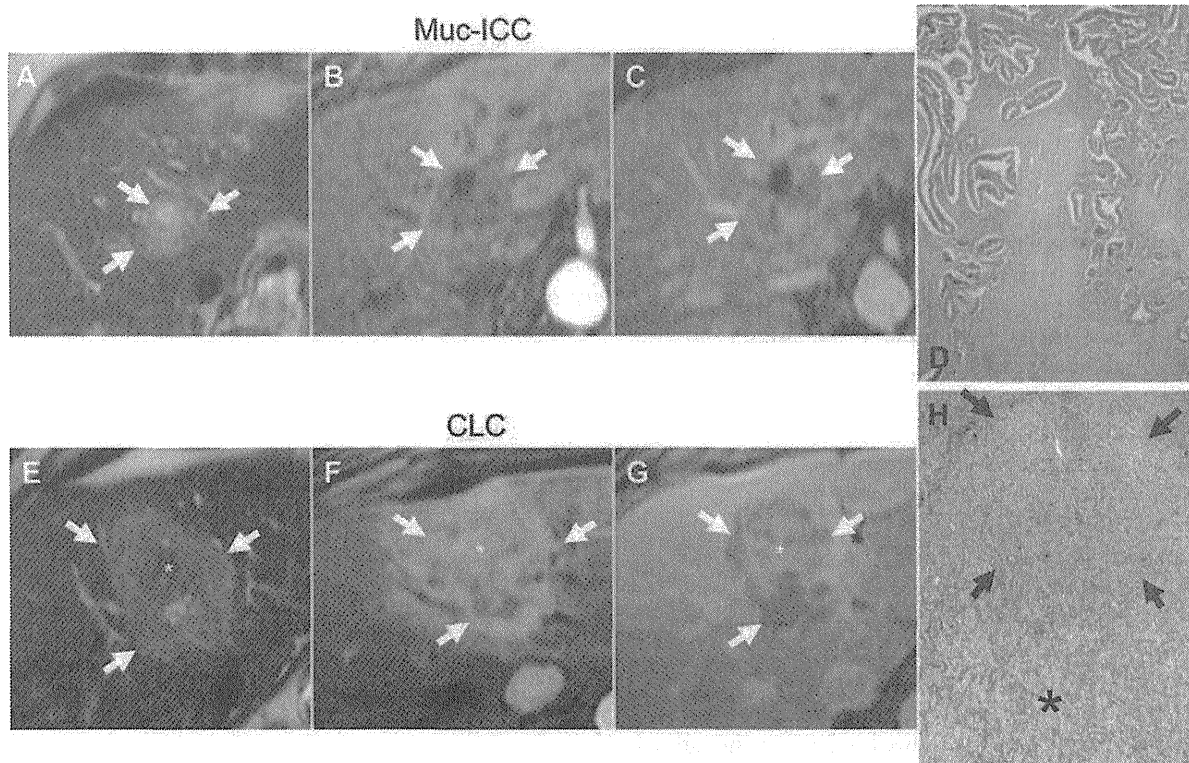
Historadiological comparison between muc-ICC and CLC. (A) T2-weighted imaging shows homogeneous, moderately hyperintense lesion (arrows) with small necrotic focus. (B) In the arterial phase, the lesion shows moderate peripheral enhancement followed by (C) progressive contrast filling in the venous phase. (D) Muc-ICC showing abundant dense fibrous stroma. (E) T2-weighted imaging shows mixed intensity (peripheral, moderately hyperintense [arrows] and central hypointense [asterisk]). (F) In the arterial phase, the lesion shows heterogeneous, strong arterial enhancement followed by (G) progressive washout in the periphery of the tumor (arrows) and delayed enhancement in the center of the tumor (asterisk). (H) CLC showing hepatocytic differentiation area located in the tumor periphery (arrows) and ductular area located in the tumor center (asterisk).
